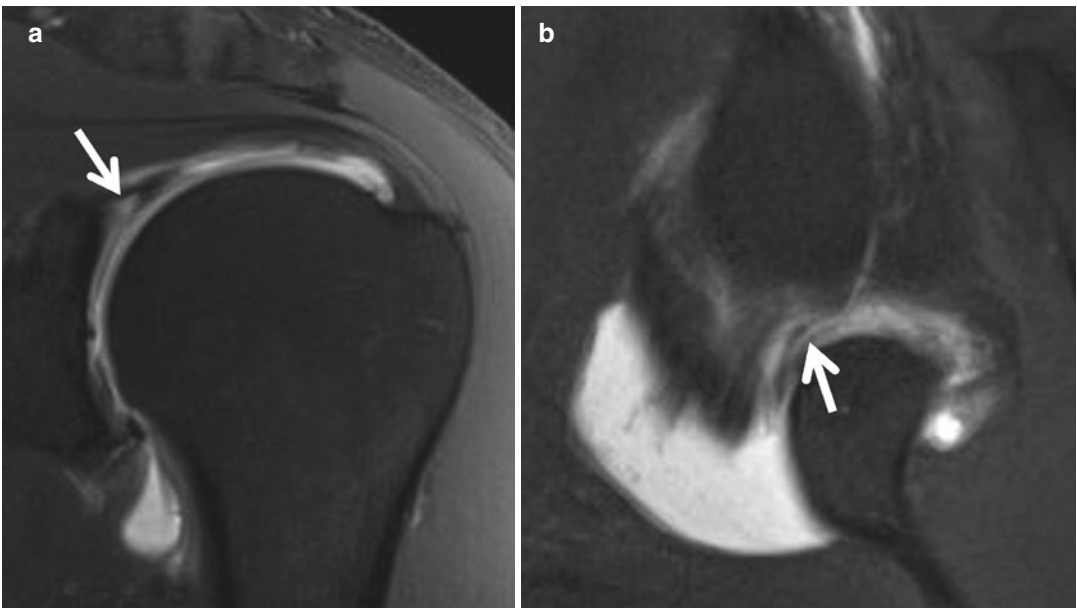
Superior labral tear on direct MR arthrography. (a) Coronal oblique and (b) ABER T1-weighted fat-suppressed images following intra-articular administration
